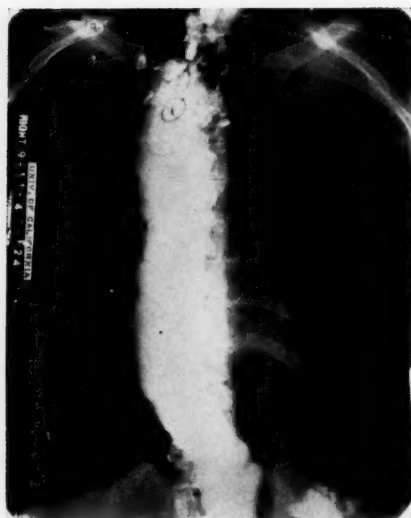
Pre-operative x-ray study shows extreme dilatation of the esophagus and narrowing of the cardia.
